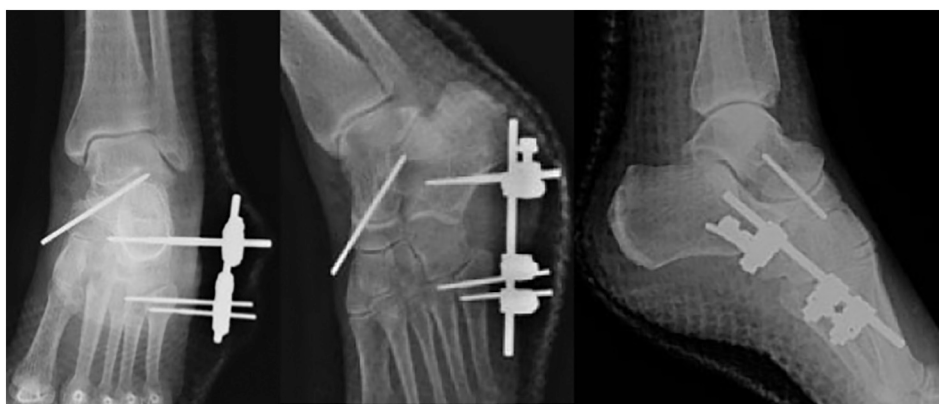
Immediate postoperative radiographic control.
